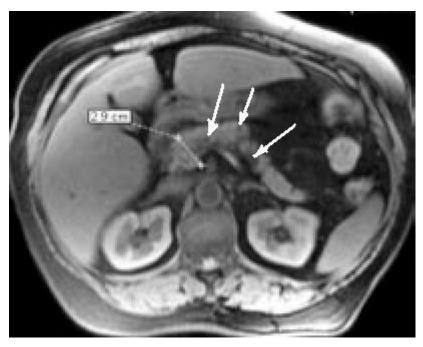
MRI of patient A., 64 years old, suffering from gallstone disease, cholecystolithiasis, chronic cholangiogenic pancreatitis: a - T1-VI in the axial plane, the head of the pancreas is increased, it is visualized clearly delimited zone of low signal (arrow 1), the signal from the process not hooklike changed (arrow 2) b -"black pancreas" on T1-WI with fat suppression in the axial plane (arrow 1), stone large gall bladder, aorta to the outgoing superior mesenteric artery (arrow 2), unmodified perivascular tissue (arrow 3); c -MRCP: calculus in the gallbladder lumen (arrow 1), CBD, tapering in the distal (arrow 2), which penetrates the head of the pancreas fibrosis; MPD uneven, deformed (arrow 3).
